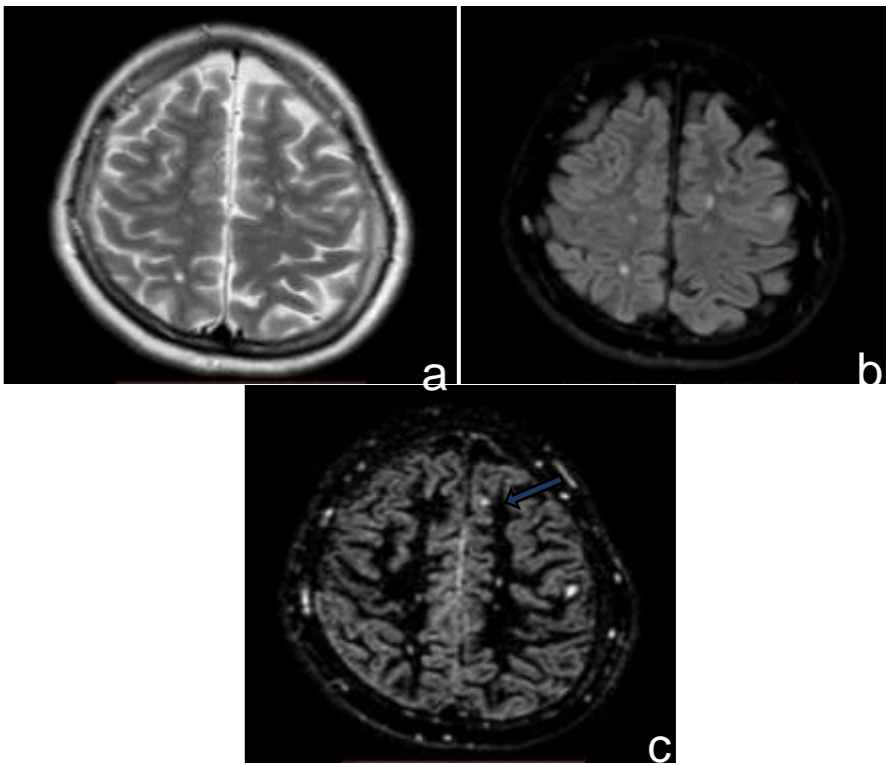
axial planes on T2WI (a) , FLAIR (b) and 3D DIR (c).The 3D DIR sequence shows a cortical lesion at left frontal lobe medially (arrow) that was not clearly identified on T2 and FLAIR images.
